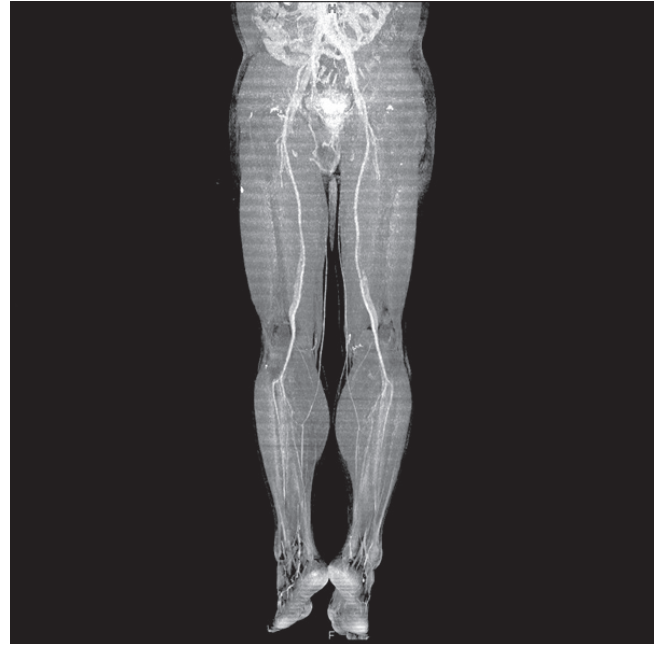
Computed tomography angiography of the lower extremities before the acute phase. The arterial systems of both lower extremities are grossly normal without remarkable stenosis or obstruction. There is no evidence of deep vein thrombosis in either lower extremity. Mild subcutaneous edema is observed in both lower legs.
